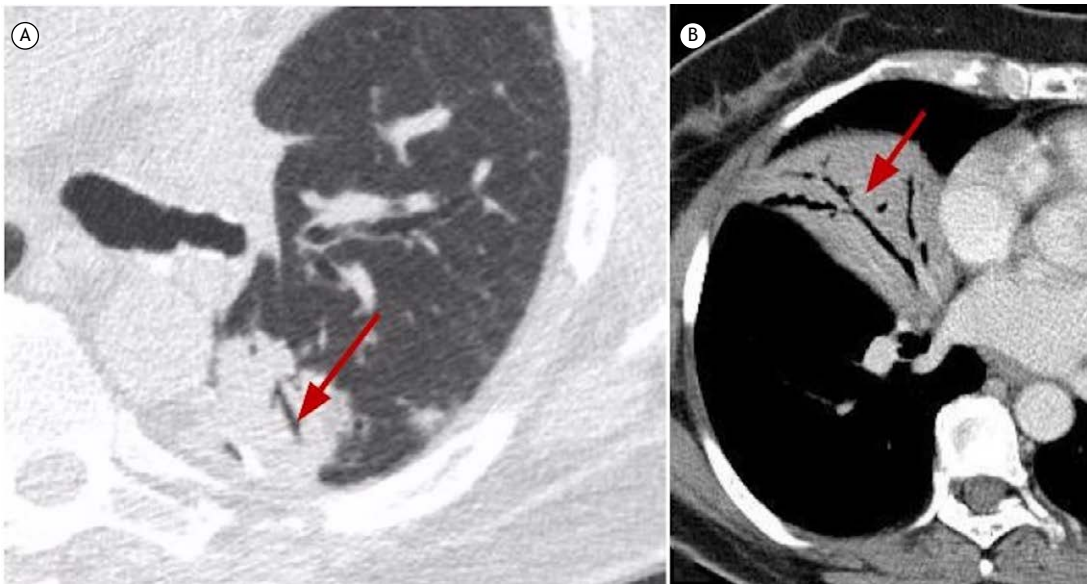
In A, an axial CT scan with lung window settings showing an air bronchogram (arrow) within a consolidation in the left lower lobe. In B, an axial CT scan with lung mediastinal window settings showing an air bronchogram (arrow) within a consolidation in the middle lobe.
